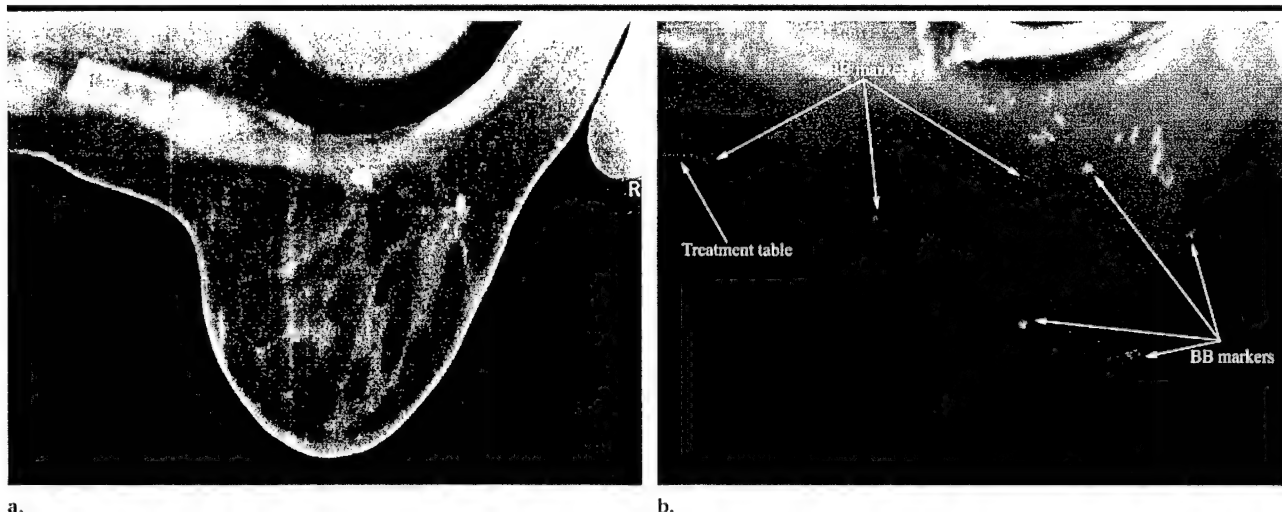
(a) Transverse CT image in patient 10, who was found after randomization not to be treatable with the proposed technique because of the proximity to the chest wall of the volume enclosed by surgical clips. (b) Transverse digital radiographic reconstruction shows that the volume delineated by the markers did not clear the treatment table.
